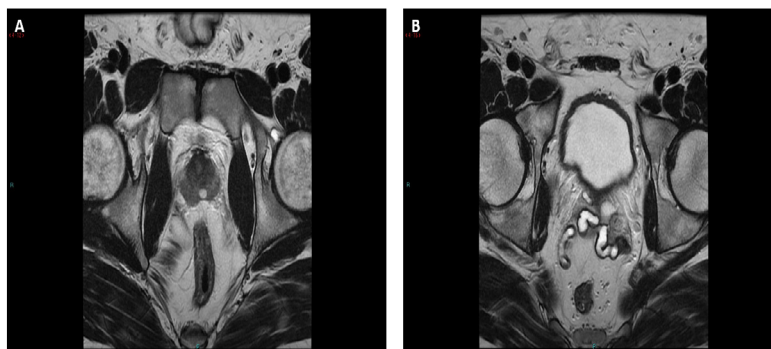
Magnetic resonance imaging of pelvis demonstrates an 8 mm midline cyst (A) and dilated seminal vesicles (B).
